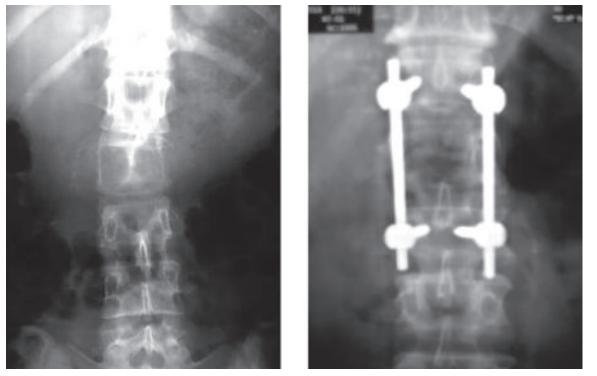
Pre and post-Operative X-ray of L-2 Aneurysmal Bone Cyst.
